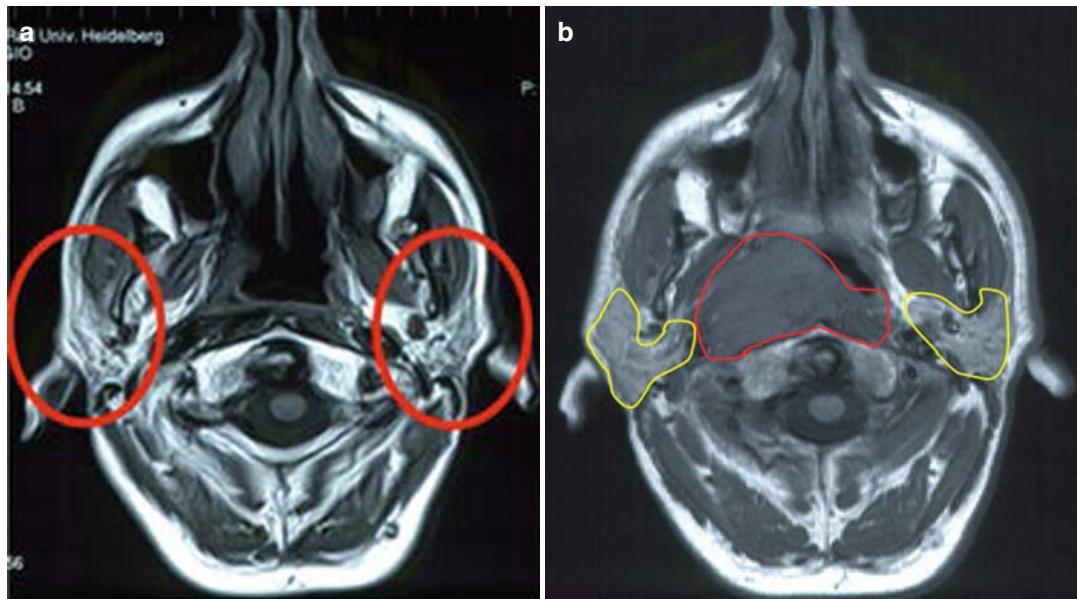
MRI of a 42-year-old man who was irradiated with conventional irradiation technique (opposed lateral fields) due to locally advanced nasopharyngeal cancer (surrounded by the red line) in proximity to the parotic
